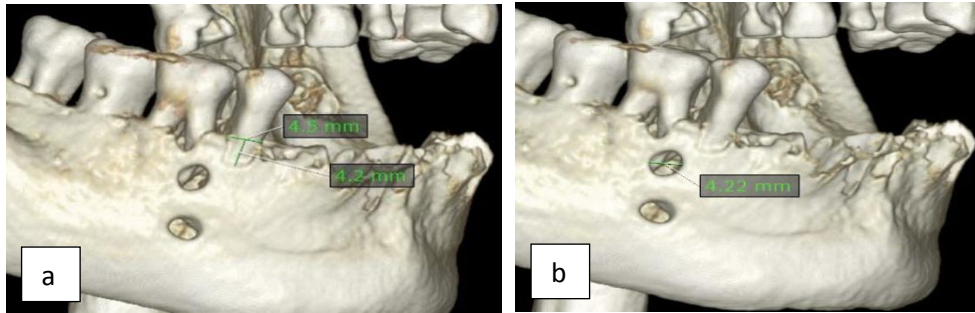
Linear measurement on volume rendered windows from On-Demand software (a). Standard resolution CBCT for dehiscence defect (b). Standard resolution CBCT from On-Demand software for fenestration defects.
